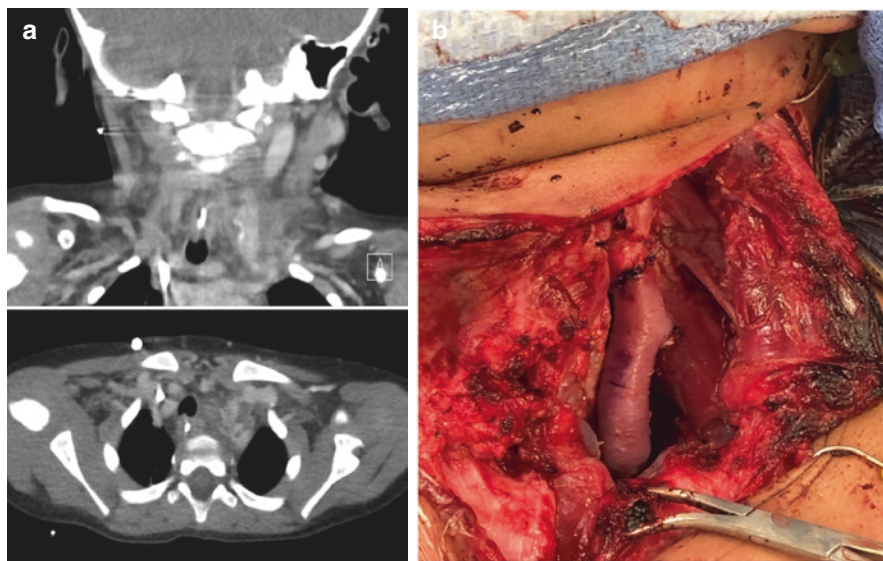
(a) Preoperative computed tomography of a child with a sarcoma in the left neck abutting the common carotid artery. (b) Left carotid artery replacement with internal jugular vein interposition graft
